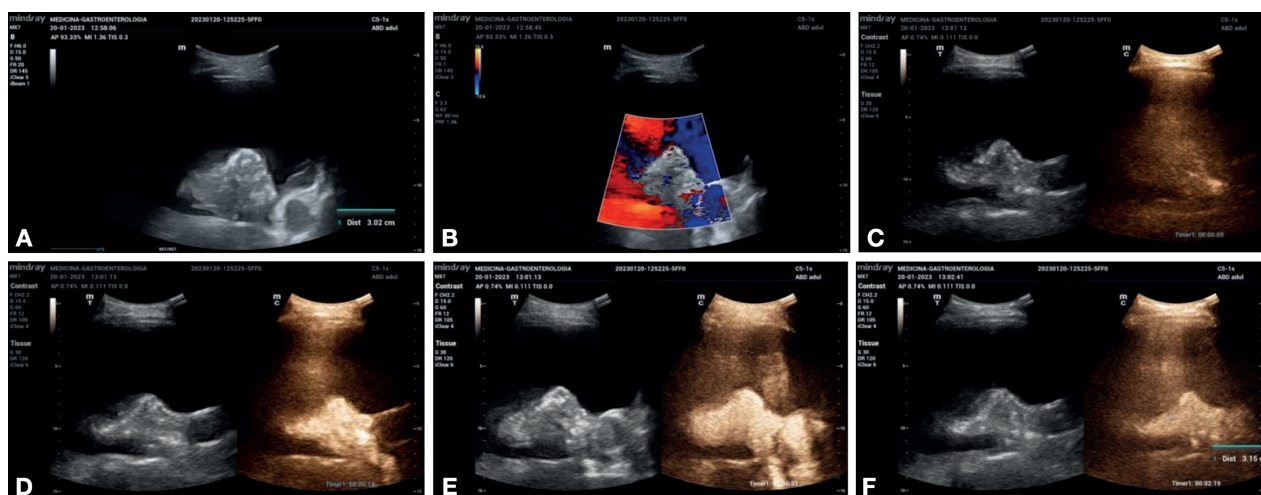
86 y old male with dyspnea and cough (with history of ischemic heart disease and smoking) CXR negative for pneumonia, but with pleural effusion. LUS demonstrated a small inhomogeneous nodule (a), negative at color-doppler examination (b); CEUS examination demonstrated an early arterial vascularization (c) and subsequent hyper-enhancement (d), with persistent vascularization in portal (e) and late phase (f).
